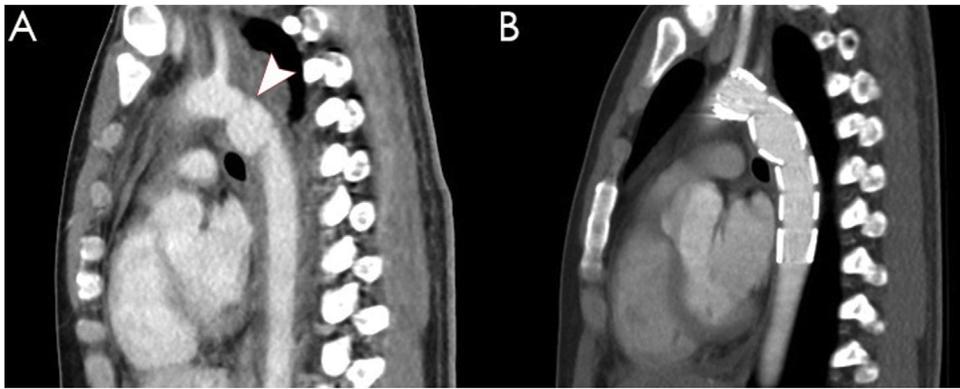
Reconstructive view of a computed tomography scan of aortic trauma. (A) An injured aorta with pseudoaneurysm formation (arrowhead). (B) An injured aorta after endovascular stenting.
